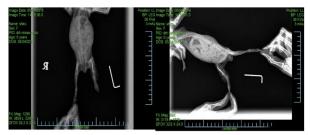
Postoperative radiographs of left tibia of the Shiro *Cavia porcellus*. A-Mediolateral postoperative radiographic displaying acceptable fracture reduction. B-Craniocaudal radiograph, the pin has not migrated and not callus formation
